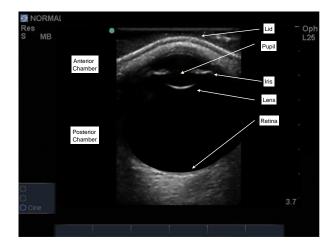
Sonographic image of orbit with structures identified.
